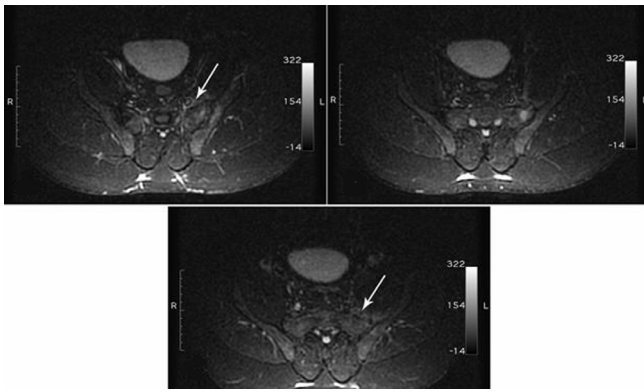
Axial T2-weighted fat suppression images reveal sacroiliitis of the left sacroiliac joint and neighboring edema pressing on the lumbosacral plexus (arrows).
